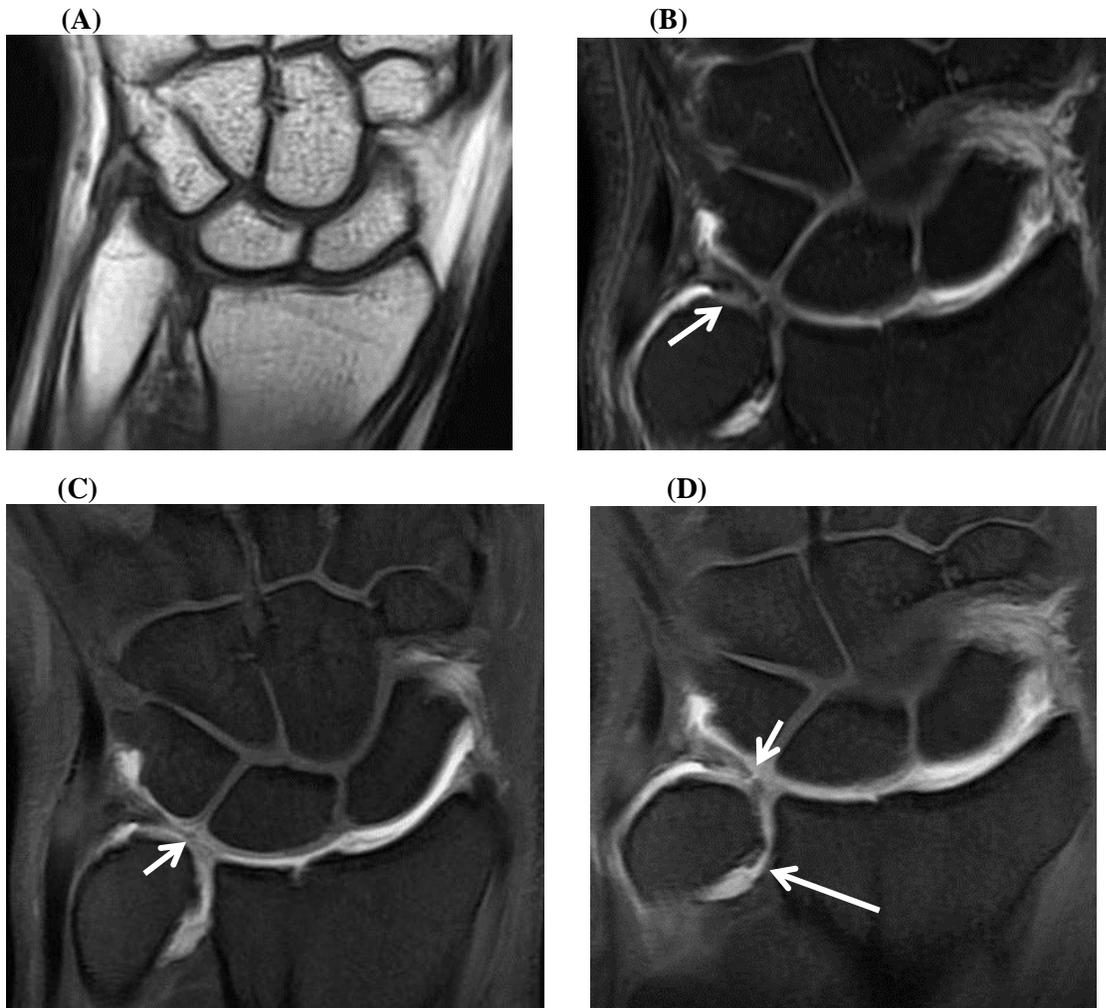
Case 2: Female patient 45 years old, complaining of chronic ulnar side right wrist pain, history of old trauma. Conventional MRI was; Coronal T1 WI & PD FS (A & B) revealed attenuated central portion of the TFC with linear central defect within the TFC (arrow in B). MR Arthrographic Coronal Fat suppressed T1 WI (C) & (D) images revealed: linear central defect within the TFC (arrow) which appears irregular and abnormal in signal with leakage of the injected contrast into the DRUJ (long arrow). Arthroscopy: confirmed the diagnosis of MRA of TFCC central perforation
